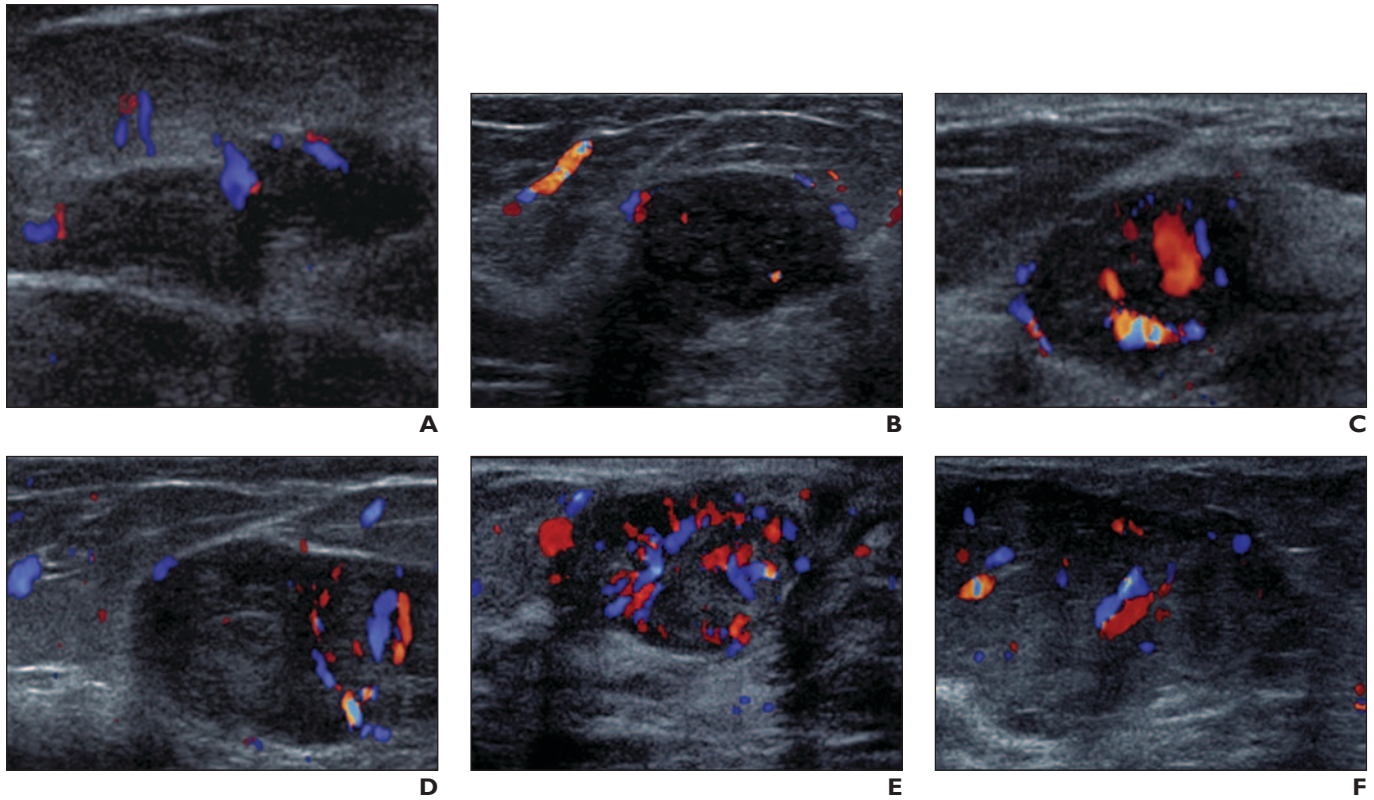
Ultrasound images of benign masses exhibiting parallel artery and vein sign.
